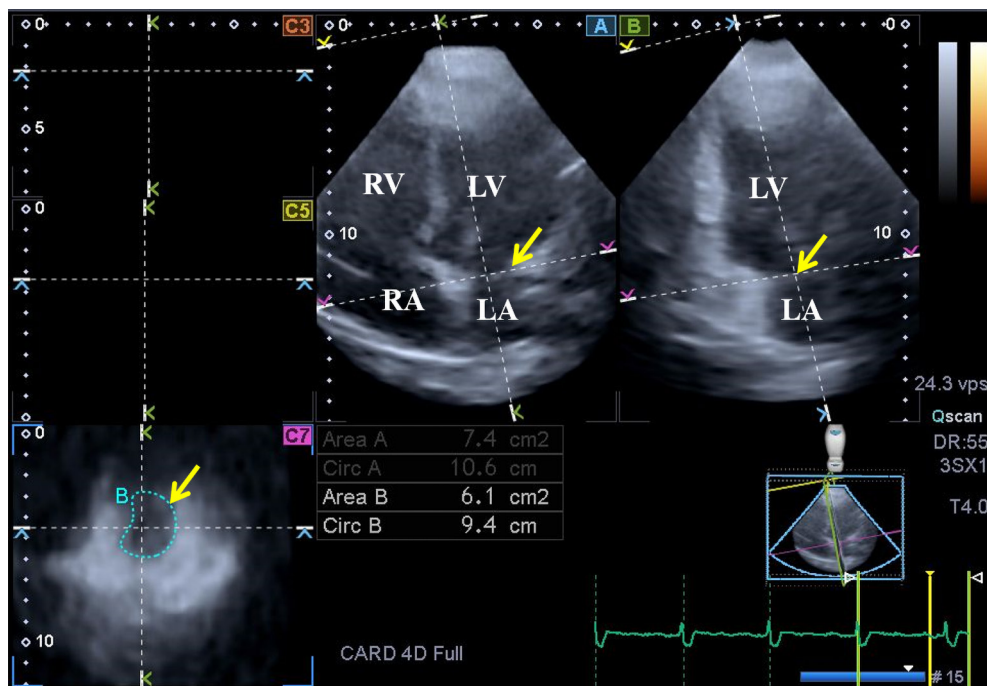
Images from a 3D full-volume dataset presenting the MA in a patient with repaired TOF: (A) Apical four-chamber view; (B) apical two-chamber view and a cross sectional view at the level of the MA (C7) optimized on apical four- and two-chamber views. The yellow arrow represents the mitral annular plane on the long- (A,B) and short-axis (C7) images. MA, mitral annulus; TOF, tetralogy of Fallot; LA, left atrium; LV, left ventricle; RA, right atrium; RV, right ventricle.
